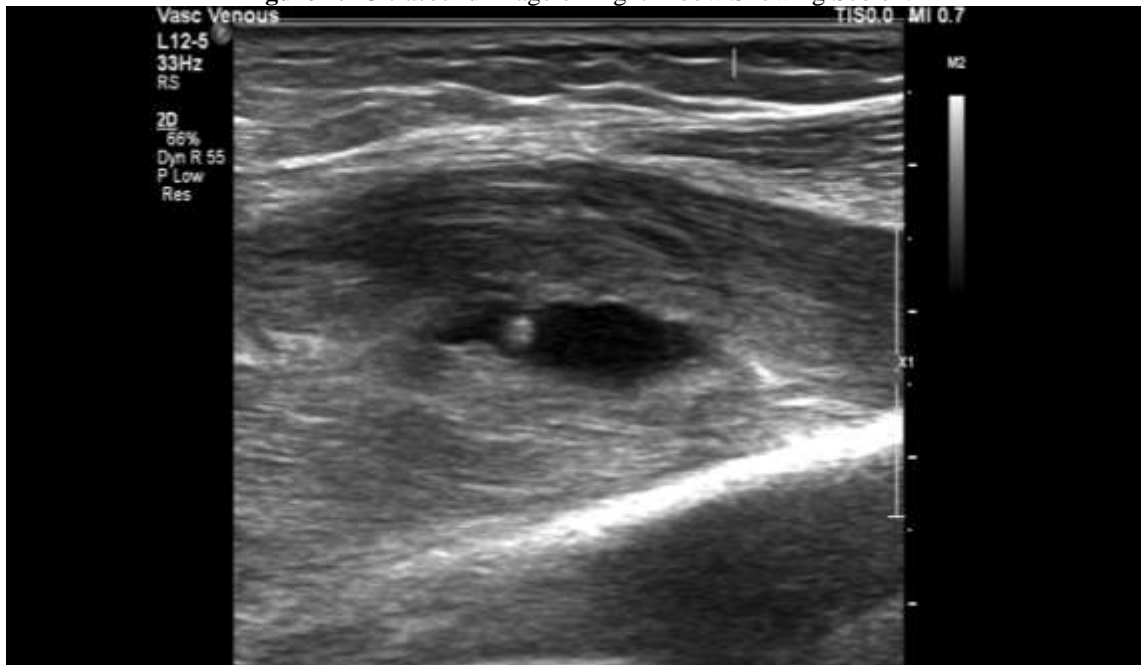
Ultrasound Image of Right Elbow Showing Resolving Lesion After 3 Weeks Of Treatment.
